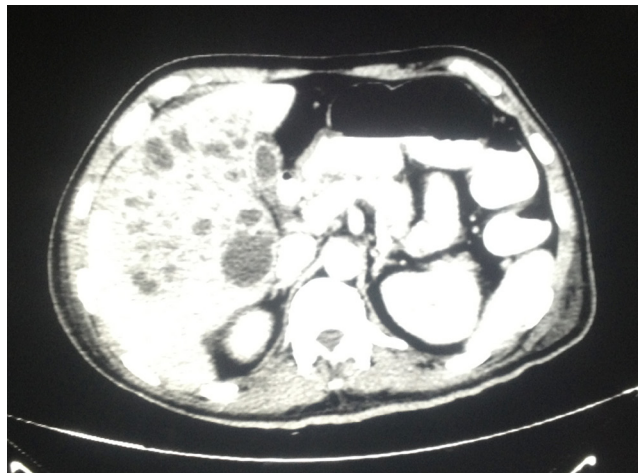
Abdominal CT scan showing hepatomegaly with an ill-defined mixed attenuating complex mass, predominantly cystic, on the right lobe of the liver
